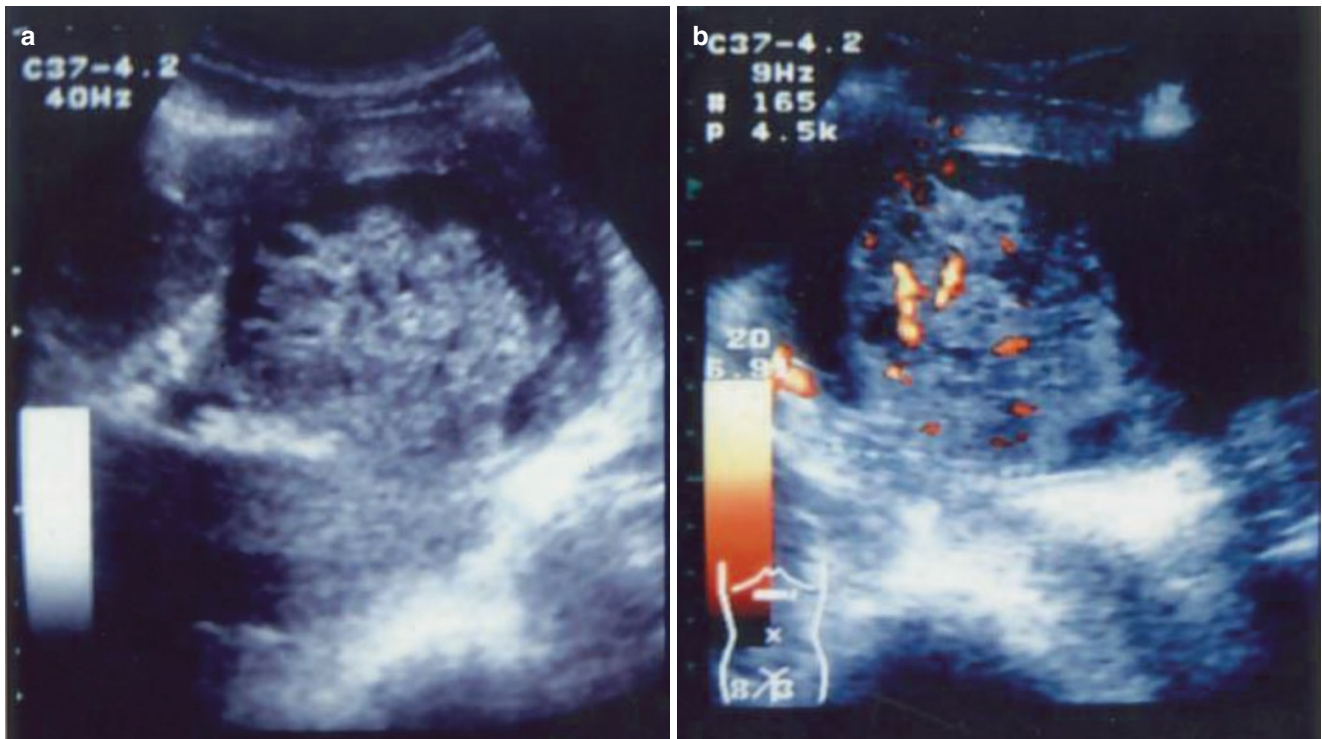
Cystadenocarcinoma; US images. US shows a high-echoic tumor surrounded by a low-echoic area (a). Doppler US shows arterial flow in the tumor (b)
